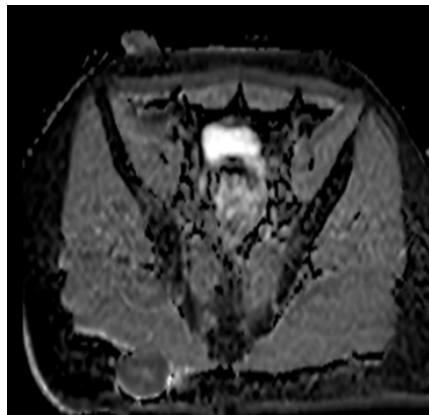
MRI T2WI image.
